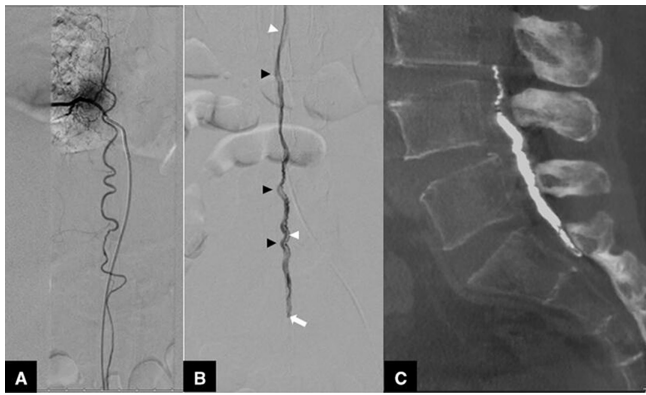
Example of filum terminale arteriovenous fistula (AVF). (a) Right T9 segmental arterial injection shows the radiculomedullary artery and contributing anterior spinal artery, which runs downward to the conus medullaris. (b) Filum terminale artery (white arrowhead) that is a caudal continuation of the anterior spinal artery feeding the AVF (white arrow), and the filum terminale vein runs upward along the filum terminale (black arrowhead). (c) Sagittal reformatted image of flat panel computed tomography after transarterial glue embolization shows glue cast in the filum terminale vein.
